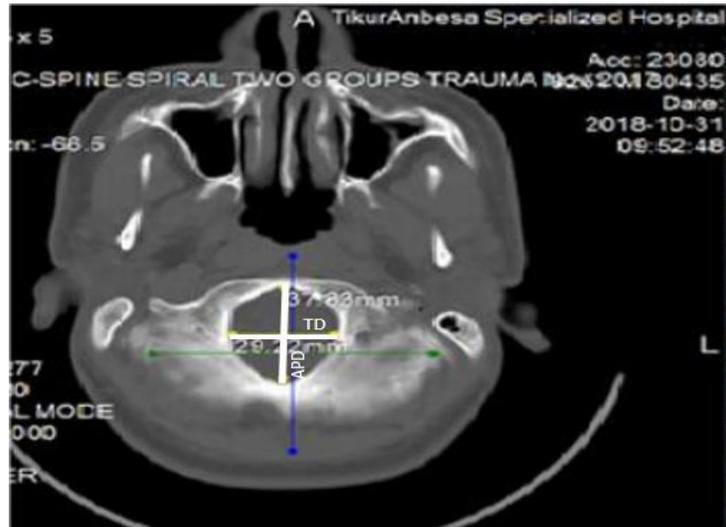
White solid lines indicating measurement of anteroposterior (APD) and transverse diameters (TD) of FM on skull CT scanned images at Tikur Anbessa Specialized Hospital, Addis Ababa
